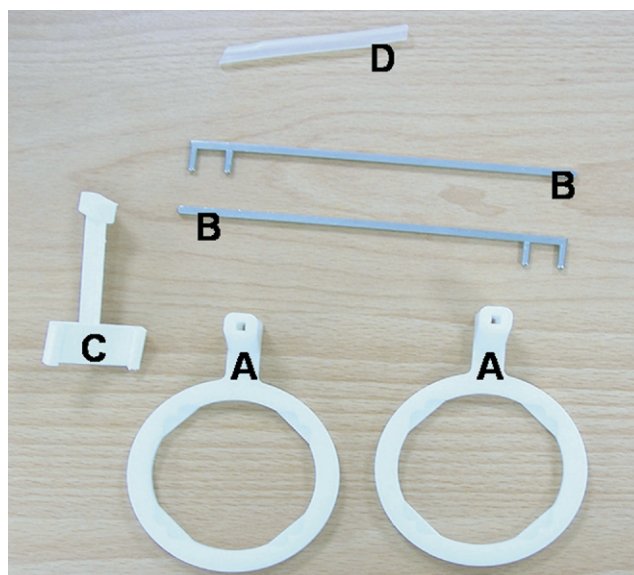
The four components (A, locator rings for bite-wing radiography; B, straight metal supporting indicator rods for bite-wing radiography; C, bite block for horizontal bite-wing radiography; and D, rubber tube) of the aiming device.
